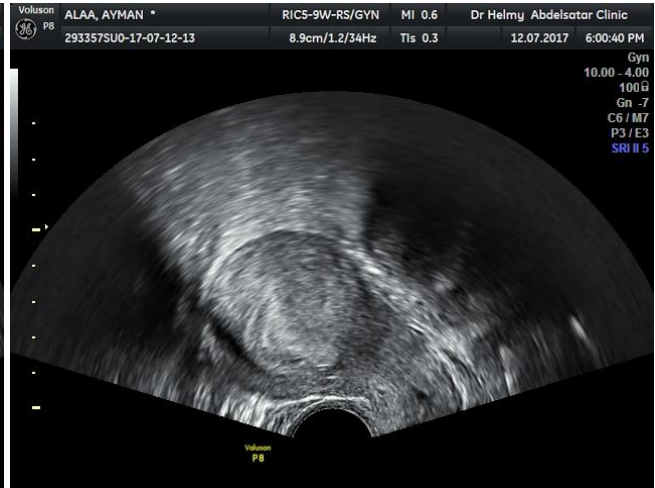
Ear sonographic sign.
